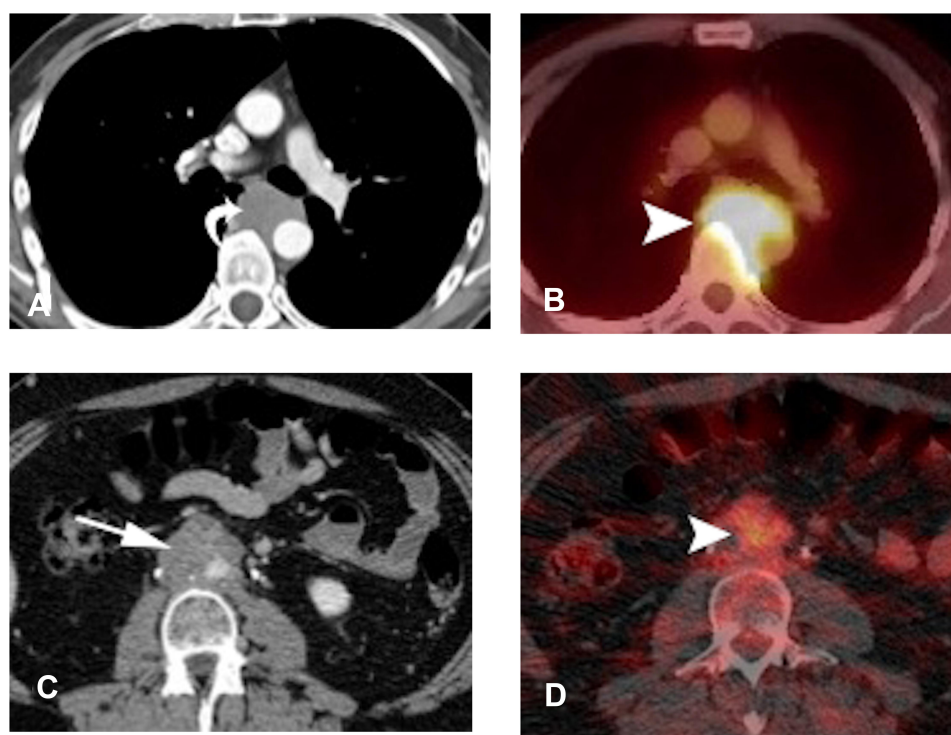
Use of FDG-PETCT in restaging. (A and B) Patient with seminoma showing mediastinal lymphadenopathy with increased FDG avidity. (C and D) Patient with NSGCT showing mildly hypermetabolic retroperitoneal lymph nodes. In both cases, FDG-PET/CT was used for treatment-response monitoring.
